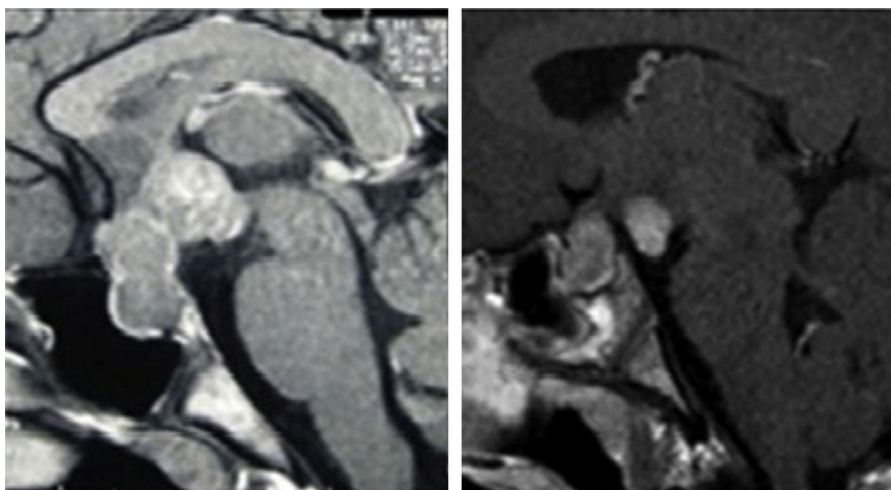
Hypophyseal MRI findings, Sagittal acquisitions, T1-sequencing after gadolinium contrast injection. Case 1. Hypothalamic-hypophyseal lesion affecting both cavernous sinuses, compression of the optic chiasm and deformation of the third ventricle. Case 2. Thickening of the hypophyseal stalk and enhanced uptake nodule in the *tuber cinereum*, measuring 7 mm in size.
